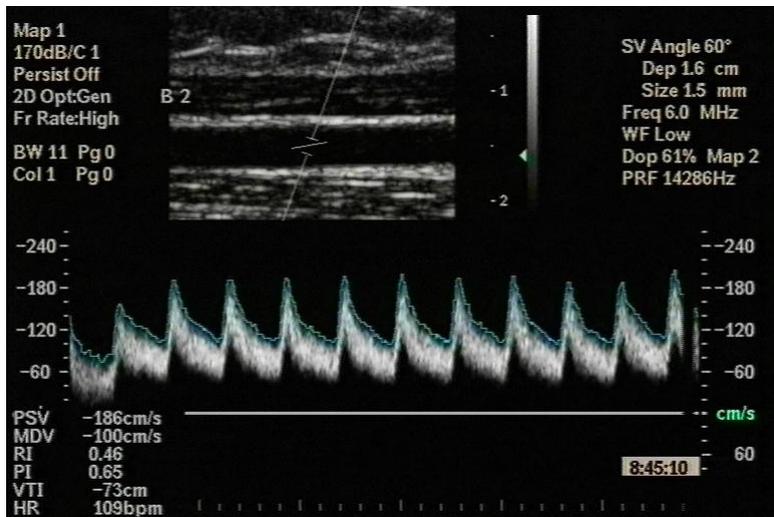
Doppler waveform image taken during reactive hyperaemia. Note increase in flow compared to figures 2.4 and 2.5.
